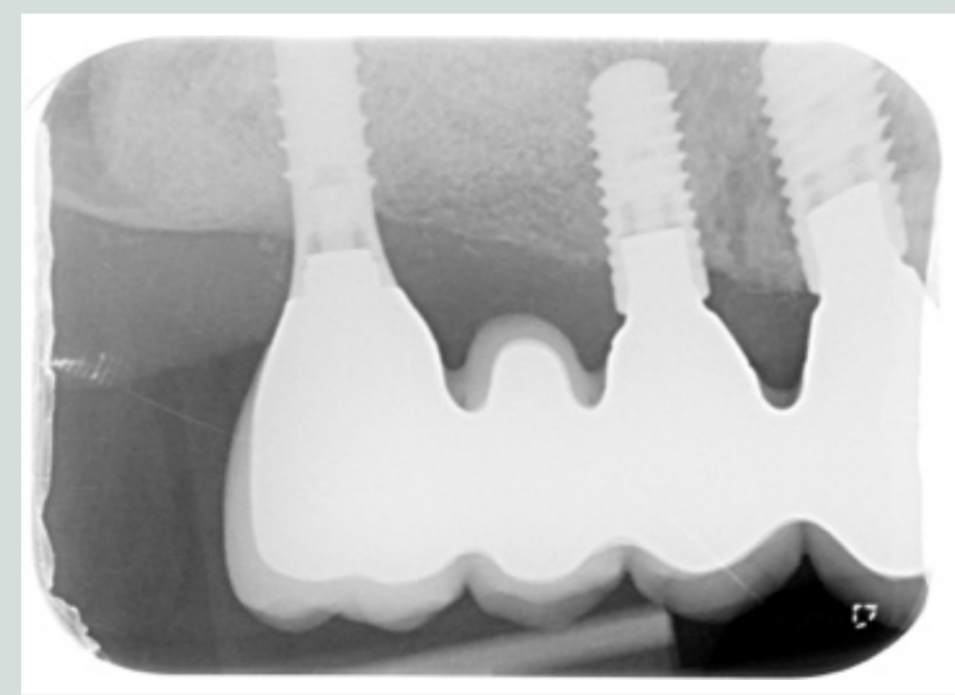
Radiographic analysis presenting periimplant tissue level / bone level measurement
